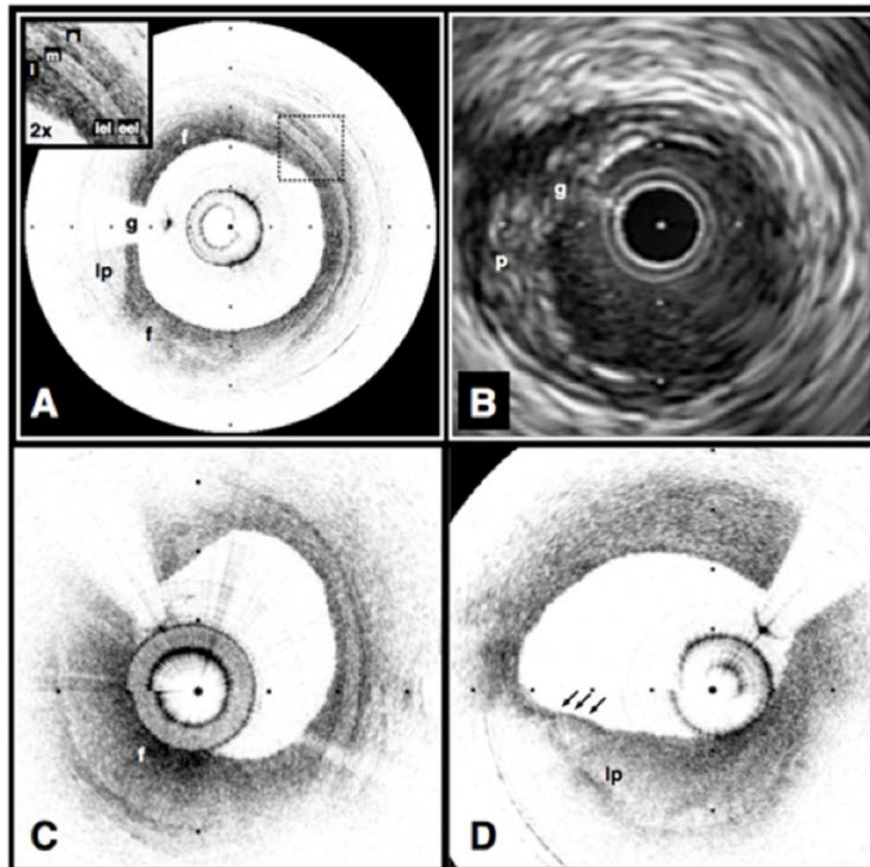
Echolucent coronary plaque imaged *in vivo* by optical coherence tomography (OCT) (A) and intravascular ultrasound (IVUS) (B). (A) An atherosclerotic plaque extending from 5 o'clock to 12 o'clock contains regions consistent with fibrous tissue (f) and a homogeneous, signal-poor region (lp), which is partially obscured by a guidewire shadow artifact (g). Fibrous plaque (C), showing characteristic high, homogeneous signal (f). Example of thin-capped lipid-rich plaque (D). Tick marks, 1 mm. OCT displayed in inverse gray scale. Reprinted from [47].
